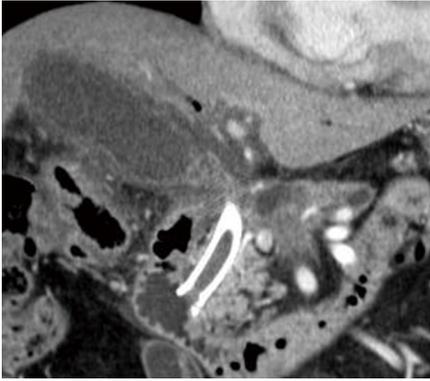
Computed tomography of the abdomen shows swelling of the gallbladder, wall thickening, and the previously placed covered metal stent.
